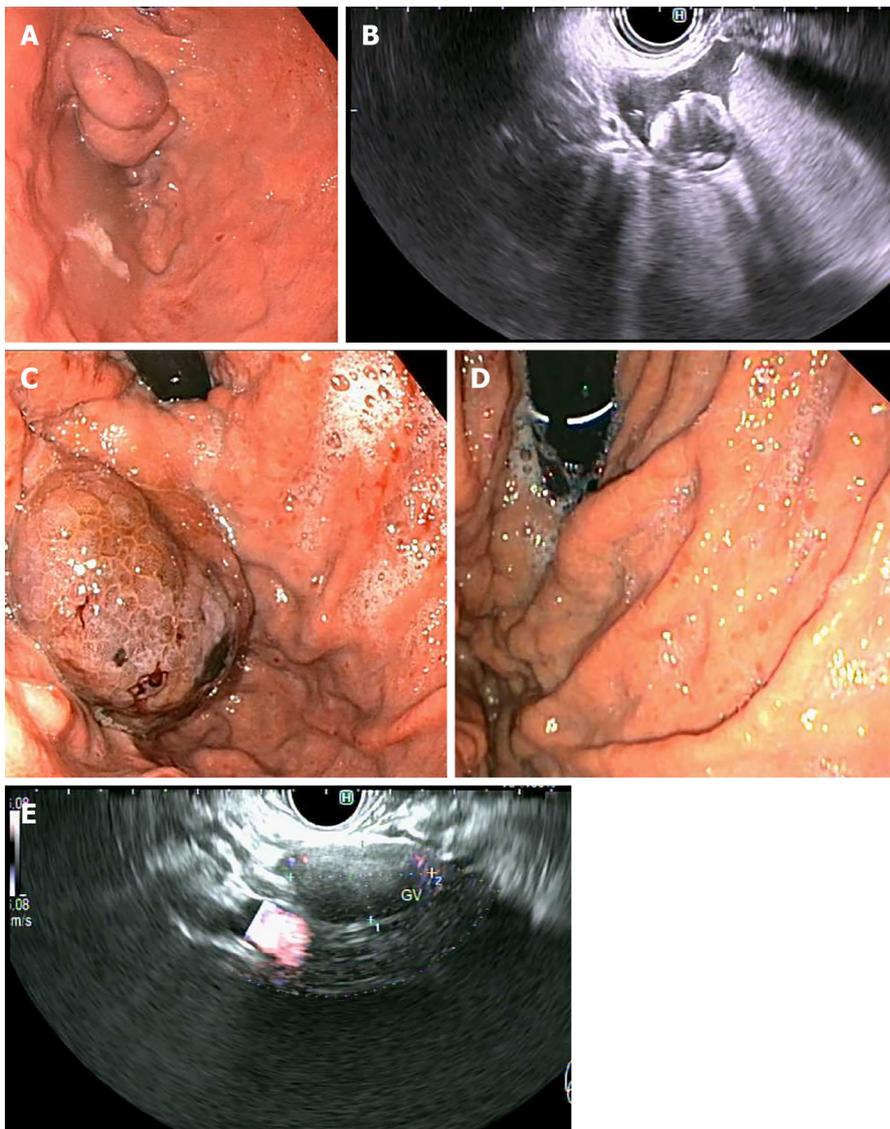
Primary prophylaxis of isolated gastric varices 1 with five 0.18 10 mm micronester coils in combination 1 mL cyanoacrylate glue. A: Pre-treatment endoscopic appearance; B: Endoscopic ultrasound (EUS) appearance immediately post-deployment of coils; C: Endoscopic appearance 1-mo post-treatment; D: Complete obliteration 4-mo post-treatment; E: EUS appearance of varix with no Doppler flow 4-mo post-treatment.
